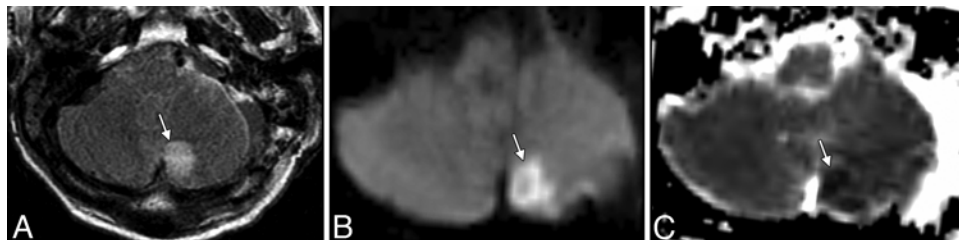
Cerebral infarction. A: Axial FLAIR MRI study showing a high signal in the medial right cerebellar hemisphere (arrow). B and C: Corresponding diffusion-weighted image (B) and apparent diffusion coefficient map (C) showing restricted diffusion (arrows).
